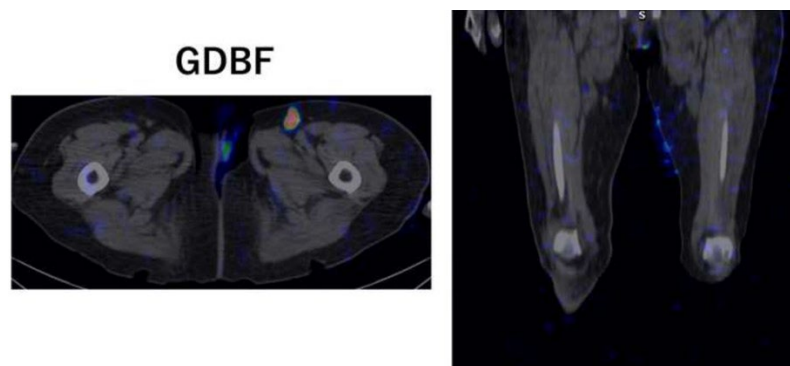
SPECT-CT images showing genital dermal back flow (GDBF). Dermal backflow was detected in the genital region.
